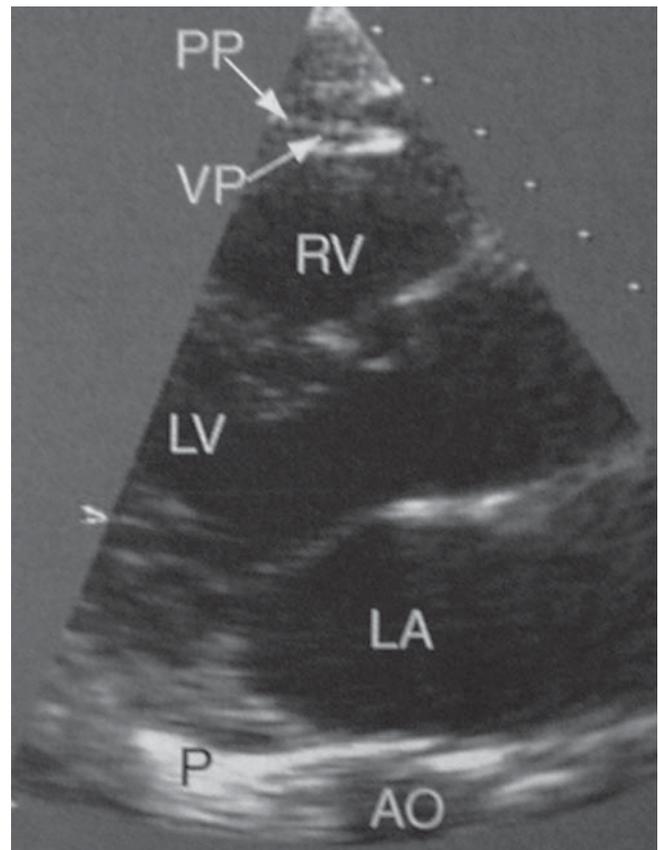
2D echocardiogram with the bright echo signals at the anterior and posterior surface of the heart representing the pericardial structures. RV right ventricle; LV left ventricle; AO aorta; P posterior pericardium; PP parietal pericardium; VP ventricular pericardium
